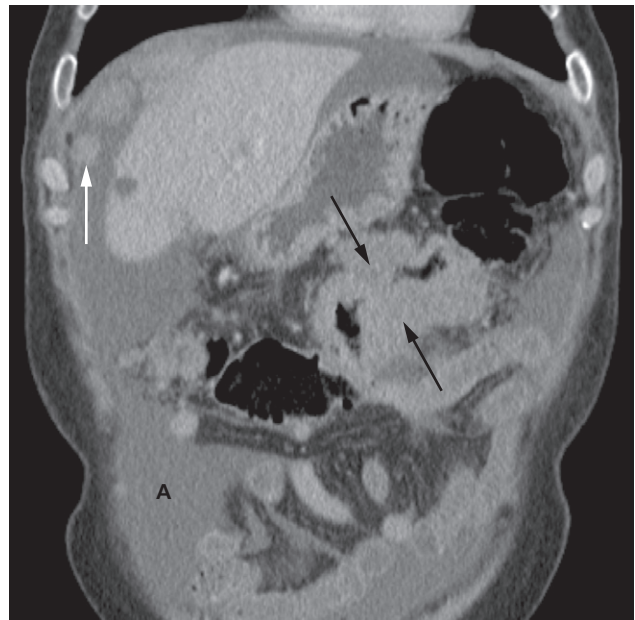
Locally advanced cancer of the transverse colon (black arrows) on a CT coronal reformat. Multiple peritoneal metastases (white arrow) are seen beneath the diaphragm and there is ascites (A) consistent with metastatic disease.
